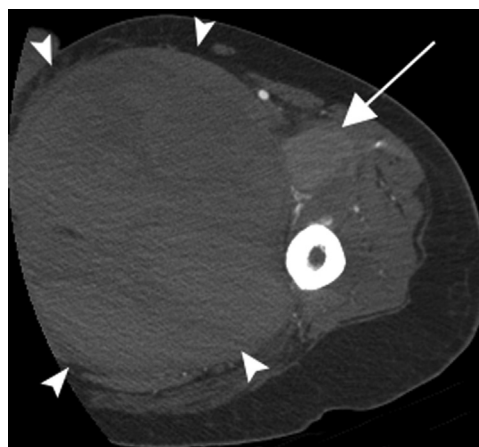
Computed tomography angiogram of the left thigh demonstrates a large expanding hematoma (arrowheads) in the medial thigh compartment. There is an ovoid, hyperdense lesion (arrow) in the anterior thigh abutting the hematoma, consistent with a pseudoaneurysm.
